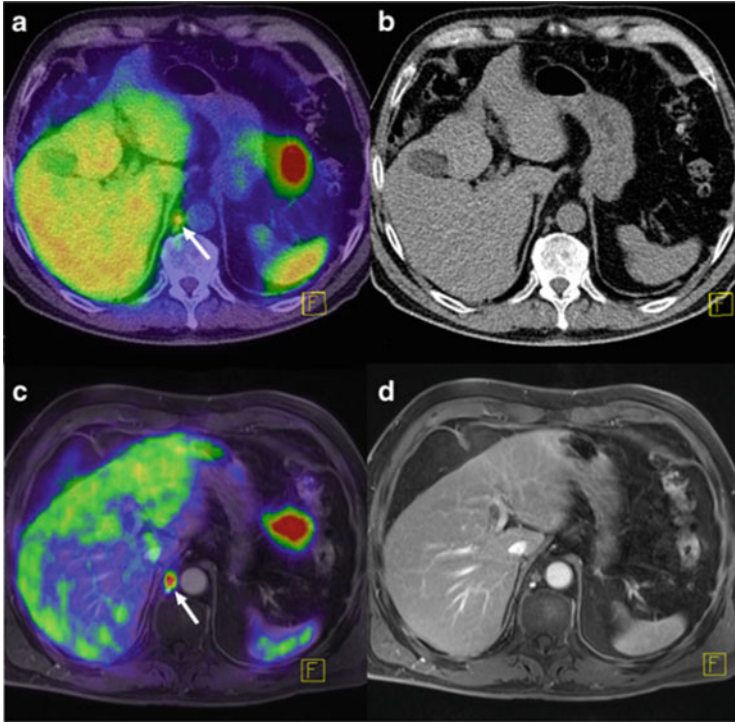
Multimodal imaging in tumor diagnosis. ^{68}Ga -PSMA PET/CT and PET/MRI images in a patient with lymph node metastases detected by PET/MRI due to a lower background signal and a time-dependent increase in PSMA tracer uptake in metastases. (a) PET/CT fusion image, (b) CT image, (c) PET/MRI fusion image, (d) MR image (T1 with contrast medium and fat saturation)
